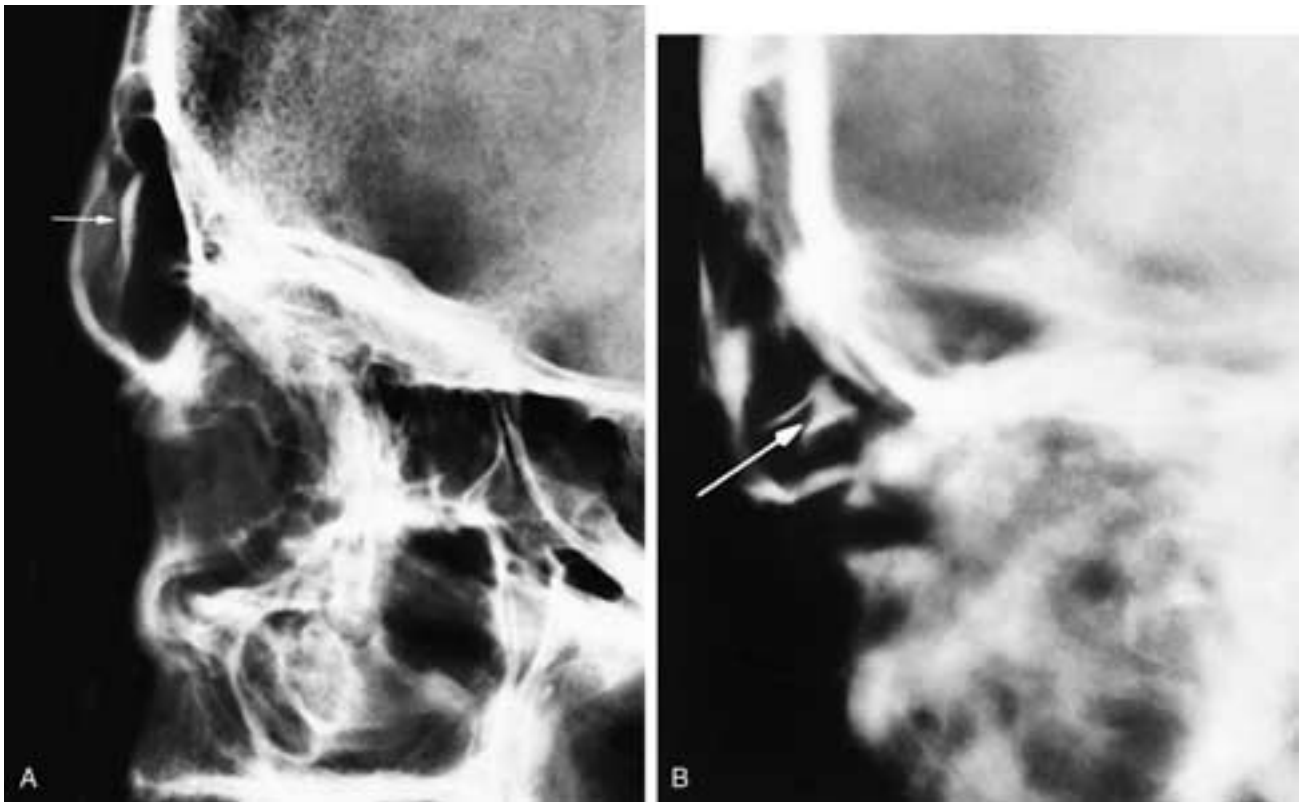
Lateral plain film (A) shows a depressed anterior frontal sinus wall fracture (*arrow*). Lateral tomogram film (B) shows a depressed fracture (*arrow*) of the anterior wall and floor of the frontal sinus.
